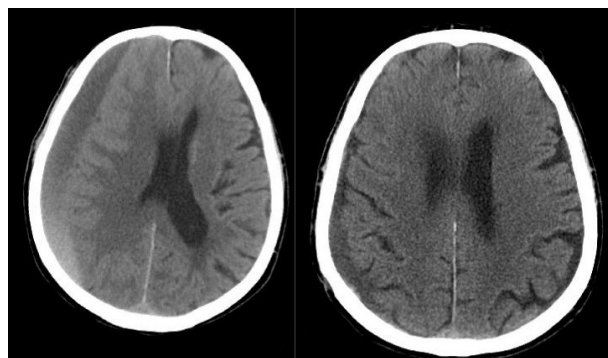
In a case with a preoperative Karnofsky's score of 80, the same Karnofsky's score could be obtained despite a residual hematoma in the postoperative CT examination
